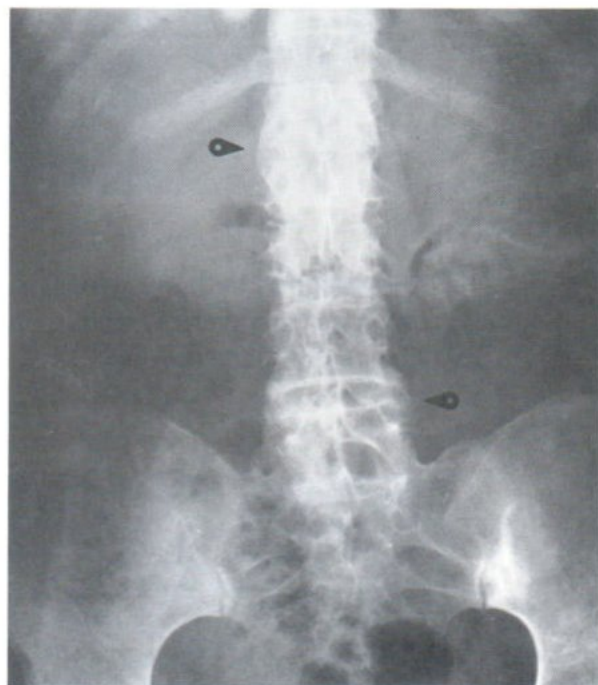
AP lumbar spine radiograph shows syndesmophytosis (round arrowheads) and hypertrophied facets. At sacroiliac joints, obliteration of the ligamentous portions is observed whereas the synovial portions show erosion and sclerosis of subchondral bones.
